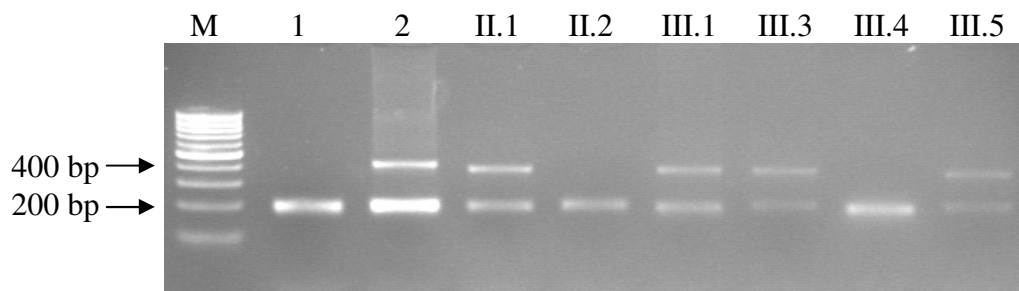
PCR amplification of the SCA8 locus for the members of the FA family (M: 100 bp ladder, 1: healthy control, 2: SCA8 (+) control; 23 and 94 (CTA/CTG) repeats)
